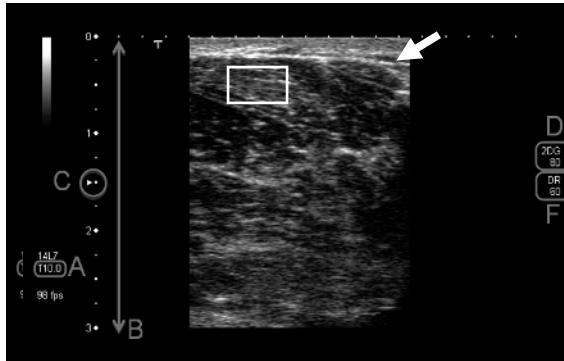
Ultrasound B-mode image with an on-screen display of probe and imaging settings. In this case, the probe is a linear array transducer with a frequency range from 7 to 14 MHz (probe label, 14L7). The selected central transmit frequency in MHz (A), imaging depth in cm (B), focal position marked by arrowheads (C), gain in dB (D) and display dynamic range in dB (F) are shown on-screen. The white arrow designates a bright echo from a boundary, and the white box outlines a zone of speckle pattern. No decrease in the average brightness of the speckle pattern with depth is apparent in this image because time gain compensation (gain that increases as a function of depth) has been applied
